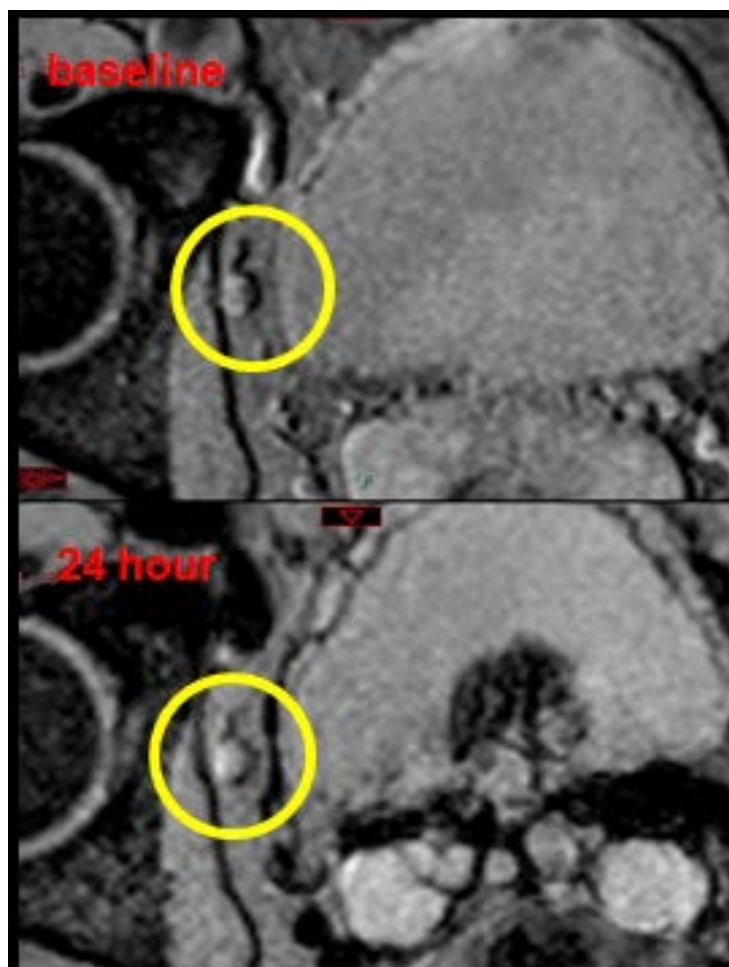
Axial T2* weighted MRI at the baseline scan demonstrates a right internal iliac chain lymph node, 24hr follow up scan after 7.5mg Fe/kg Ferumoxytol injection demonstrate a homogeneous hyperintense signal within the lymph node, which is suspicious for malignant involvement.
